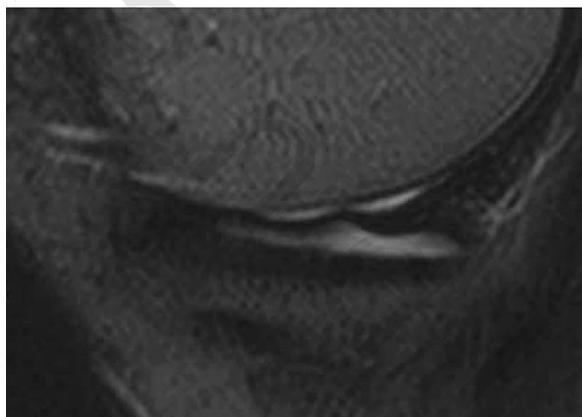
T2-weighted fat-saturated sagittal image demonstrating a flounce like appearance to the posterior horn and body of the medial meniscus, in the setting of a meniscal tear.⁽²⁵⁾
